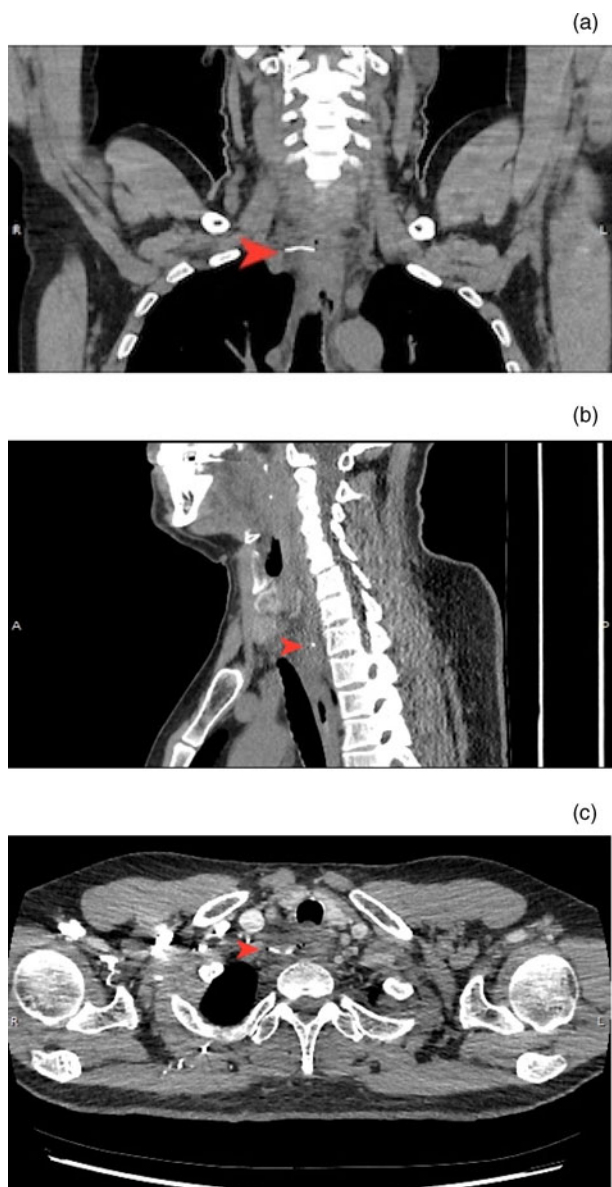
(a) A coronal contrast computed tomography scan showing a radiopaque foreign body at the thoracic inlet. (b) A sagittal cut demonstrating the foreign body at the level of T1, presumed to be within the oesophagus lumen. (c) An axial view of the thin, curved foreign body, reported to be a bone. (Arrows indicate foreign body.)
